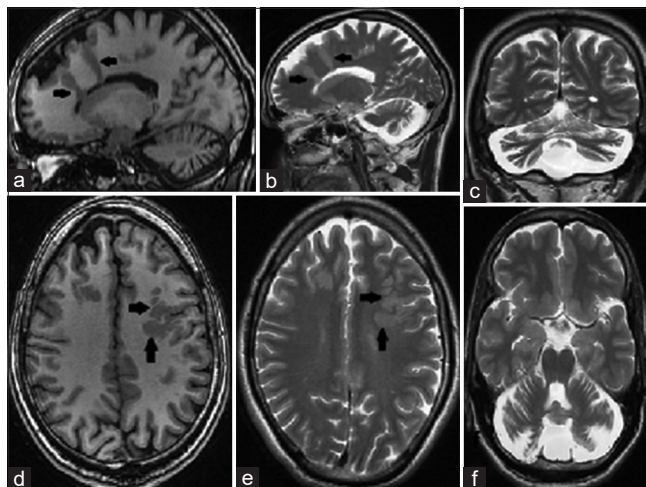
Magnetic resonance imaging (MRI) T1- (a) and T2- (b) weighted sagittal images showing continuous layer of gray matter in the right frontal lobe (arrows) at two sites extending from ventricular wall to cortex and causing bulge on the ventricular wall without intervening CSF cleft suggesting transmantle heterotopia (typical imaging features to differentiate from closed lip schizencephaly). T1- (c) and T2- (d) weighted axial MRI images showing multiple foci of gray matter in the left frontal lobe (arrows) suggesting subcortical heterotopia. T2-weighted coronal (e) and axial (f) MRI images showing bilateral cerebellar and vermian atrophy
